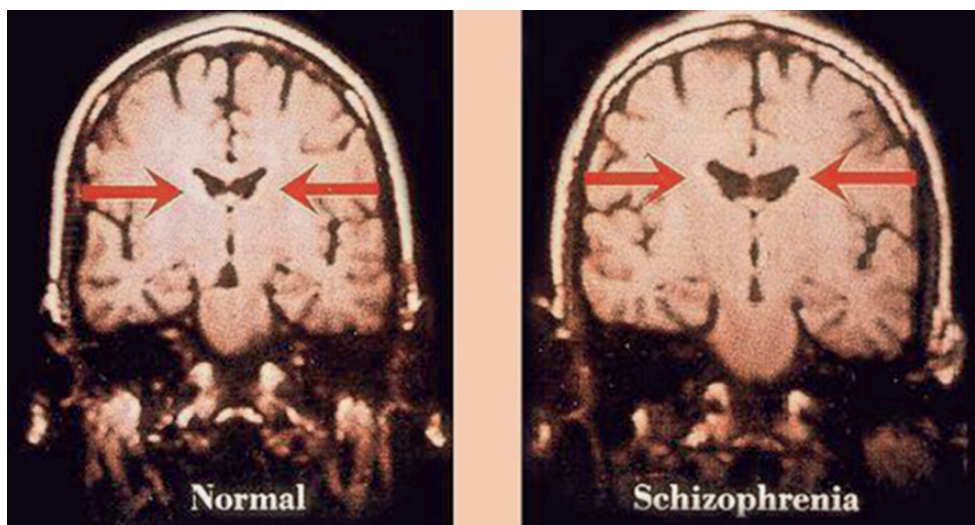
Ventricular size in monozygotic twins discordant for schizophrenia. Coronal MRI scans of twins discordant for schizophrenia show lateral ventricular enlargement in the affected twin (reprinted with permission from the Massachusetts Medical Society (179). All rights reserved) (see Color Plate 2, following p. 650).
